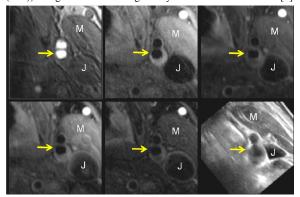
A corresponding slice of a 3D ultrasound image (lower right) is displayed with 5 contrast weightings in a MRI exam.
